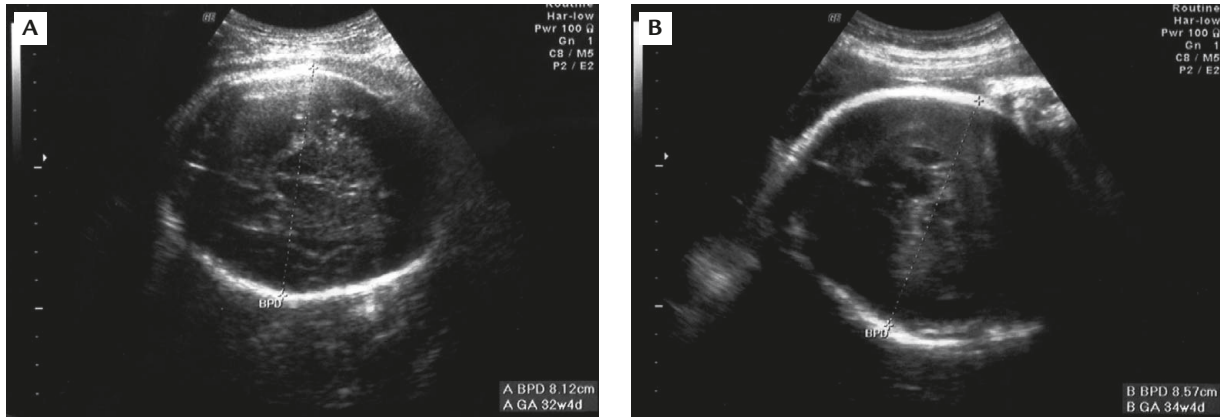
Prenatal ultrasound at 36 weeks of gestation. (A) The normal brain structures can be identified clearly in twin A. (B) Relatively diffuse lower echogenicity is seen in twin B.
